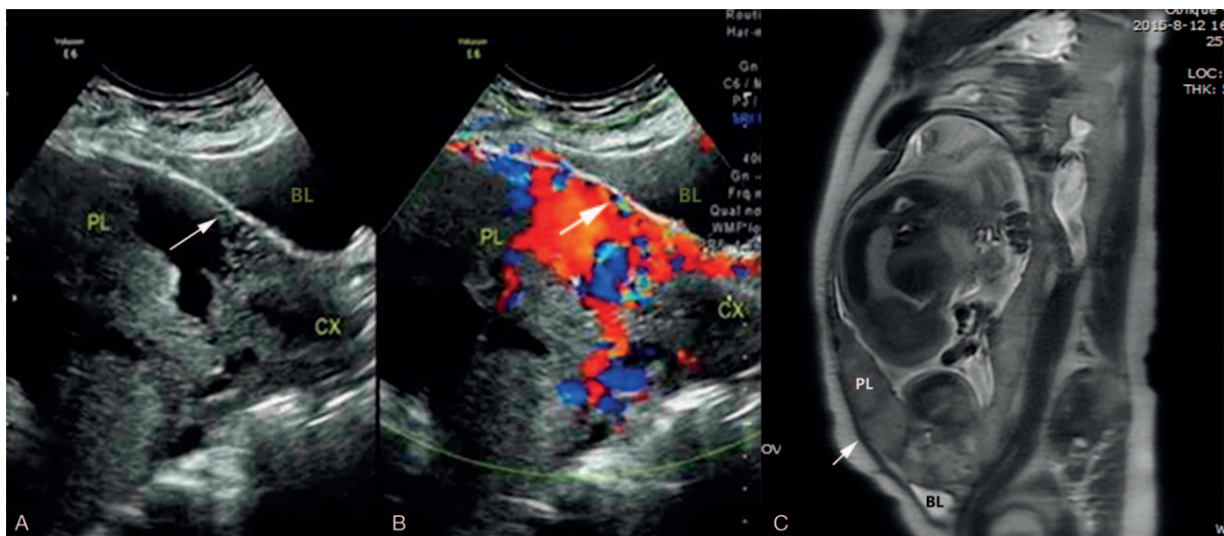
(A and B) Arrow in color Doppler images indicates evidence of placenta accreta (hypervascularity of uteroplacental interface). (C) MRI shows placenta accreta in the lower uterine segment (arrow). BL=bladder, CX=cervix, PL=placenta.
